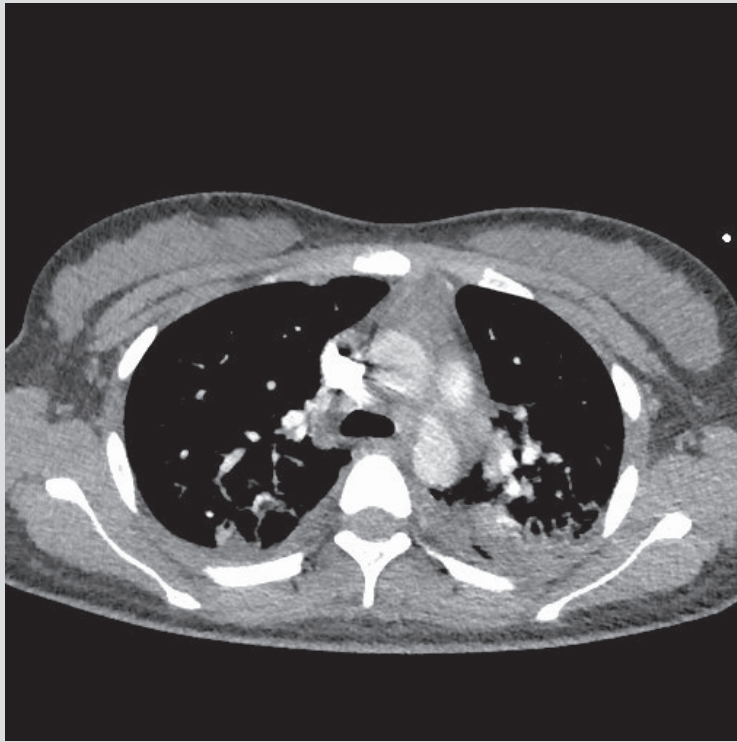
CT pulmonary angiogram showing infiltrates bilaterally with small pleural effusions
